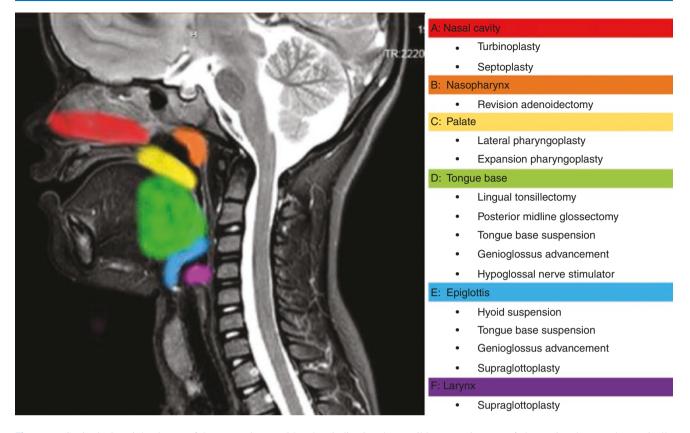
Sagittal T2-weighted MRI of the upper airway with colors indicating the possible anatomic areas of obstruction that may be surgically addressed for obstructive sleep apnea
